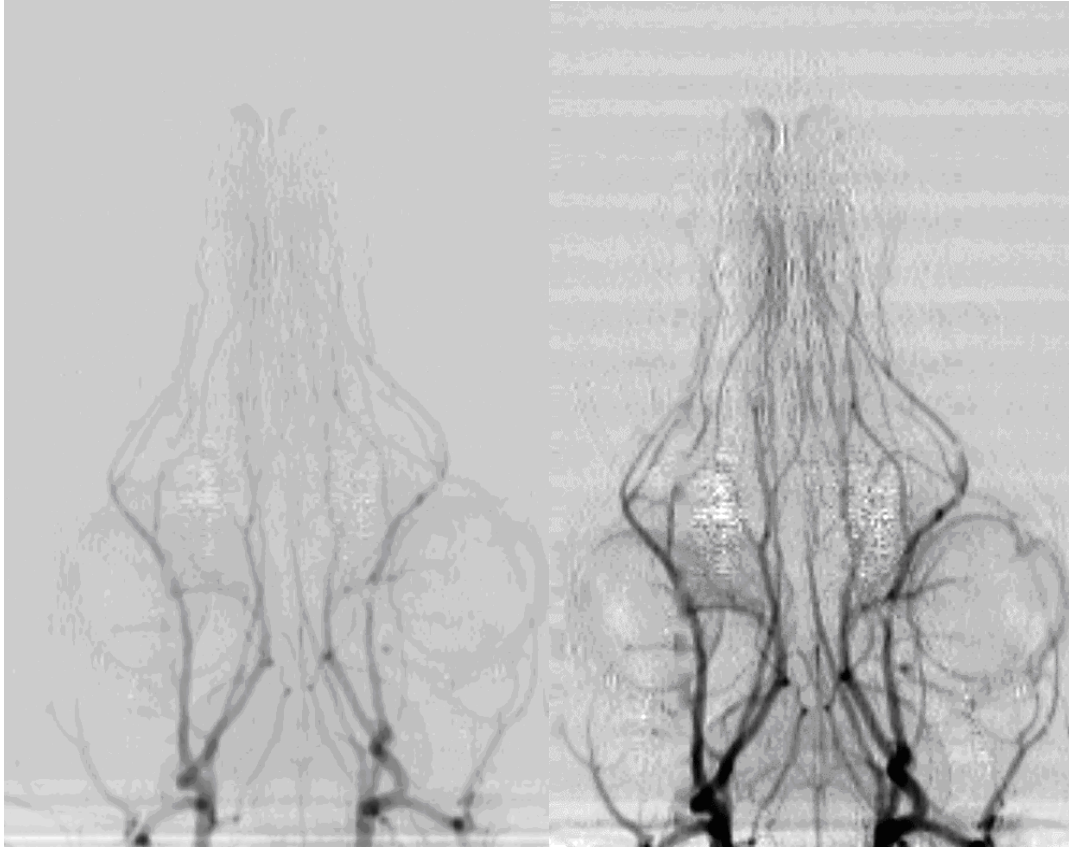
Image of intracerebral arteries acquired in radiography mode with the germanium detector in antero-posterior projection, using synchrotron K-edge digital subtraction angiography. (a): early filling phase (b): late filling phase. (reprinted with permission)
